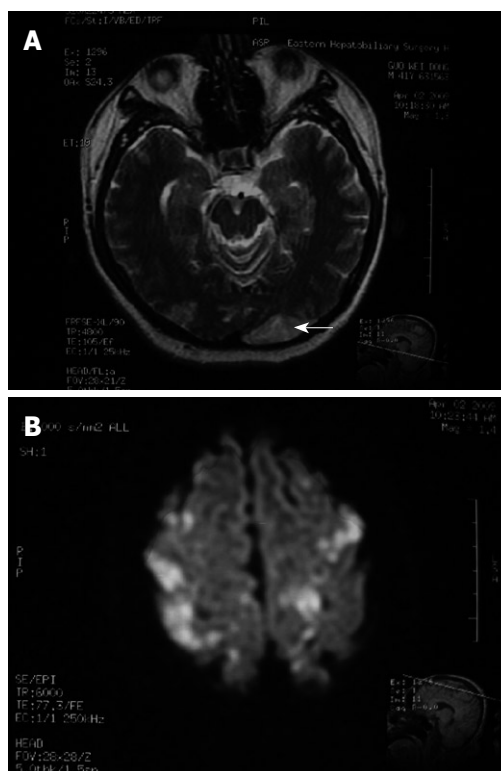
Cranial magnetic resonance imaging (MRI) obtained after the second TACE procedure. A: cerebral lipiodol embolism (arrow); B: cerebral lipiodol embolism (multiple high signals).
